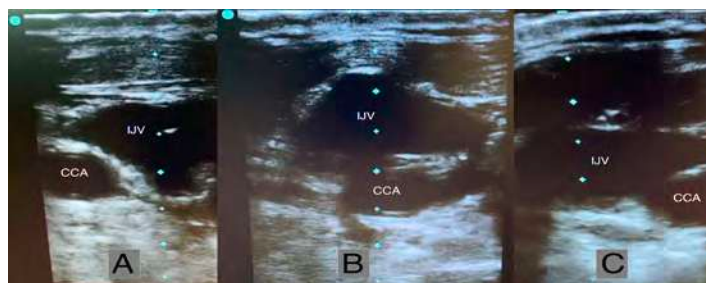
(A) Ultrasonography of patient's left neck in a neutral position showing the common carotid artery (CCA) lateral to the internal jugular vein (IJV), (B) coursing posteriorly as it travels caudad in a rotational trajectory, and (C) ultimately reaching its typical orientation medial to the IJV.
